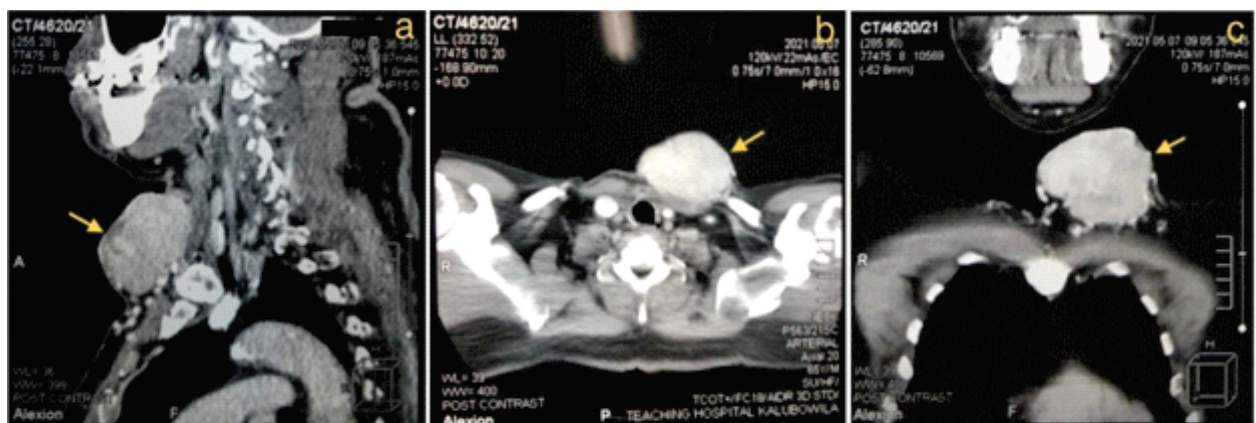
CT images (a) sagittal, (b) axial and (c) coronal sections of the neck region; arrows showing the lump.
